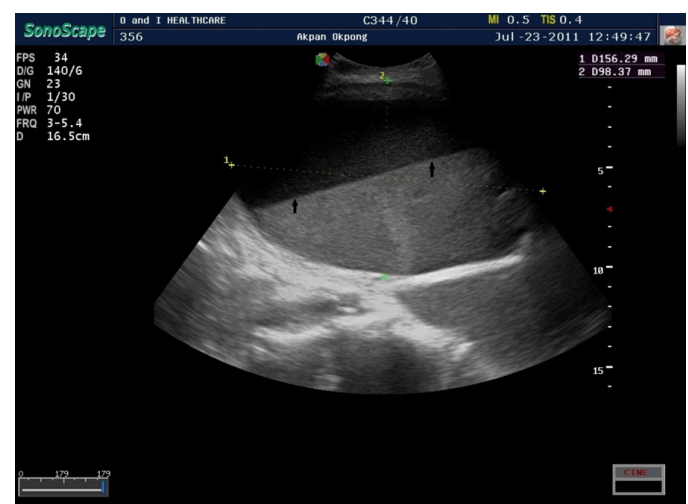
Ultrasound scan showed distended urinary bladder with fluid-fluid level (arrows).
